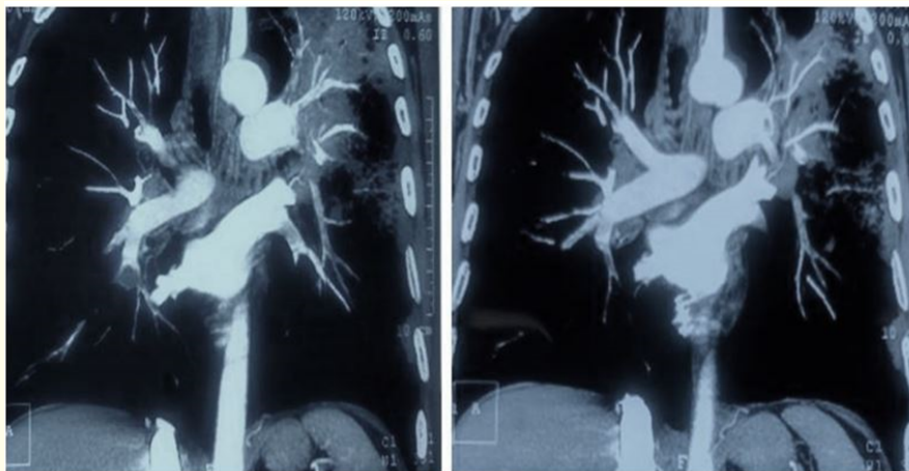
Computed tomography pulmonary angiography in coronal section.
